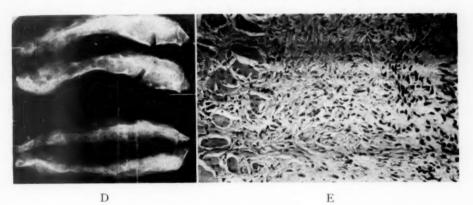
(D.) The roentgenogram of the excised tenth rib shows translucent areas traversed by bony trabeculae. The translucent areas on the roentgenogram, indistinguishable from cysts, were composed of fibrous tissue except for one cyst which was 1.5 by 1 cm. in size.
